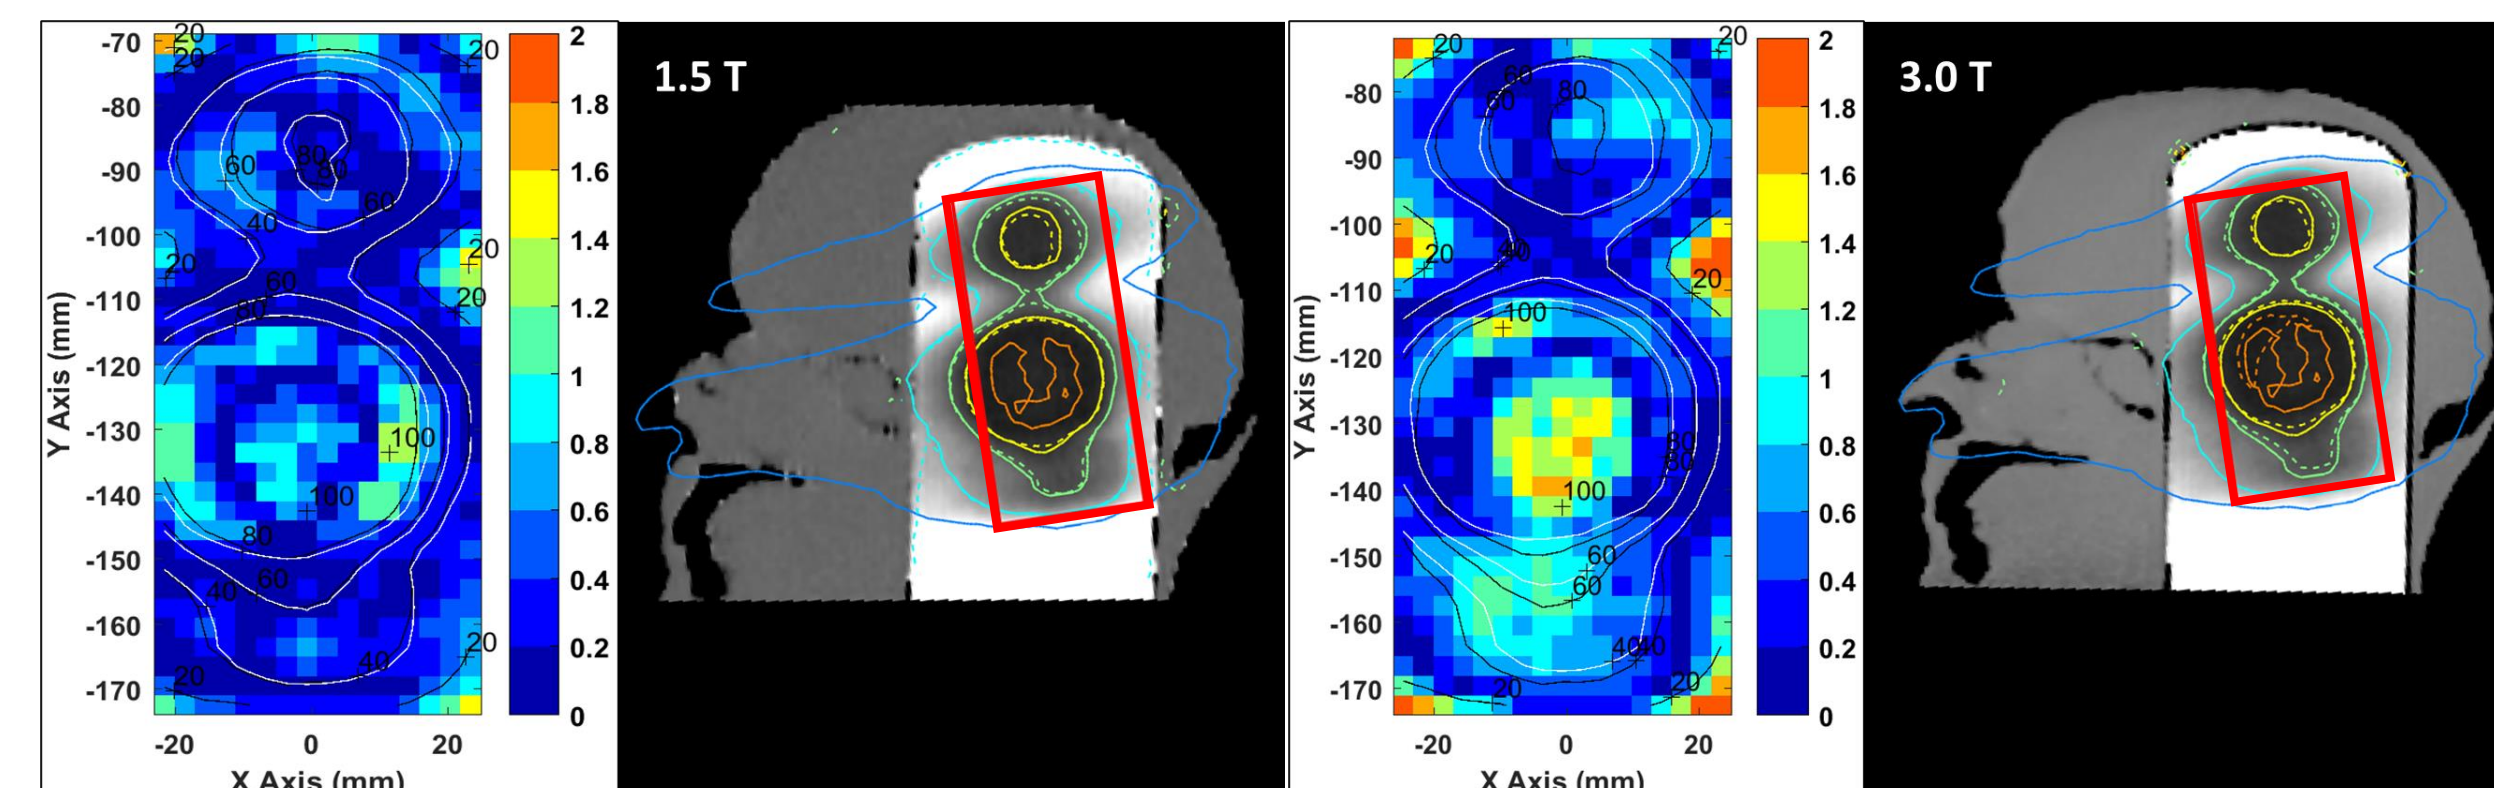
2D Gamma Index analysis on 1.5T and 3.0T MRI scanners in sagittal plane at the location depicted by the red area.
